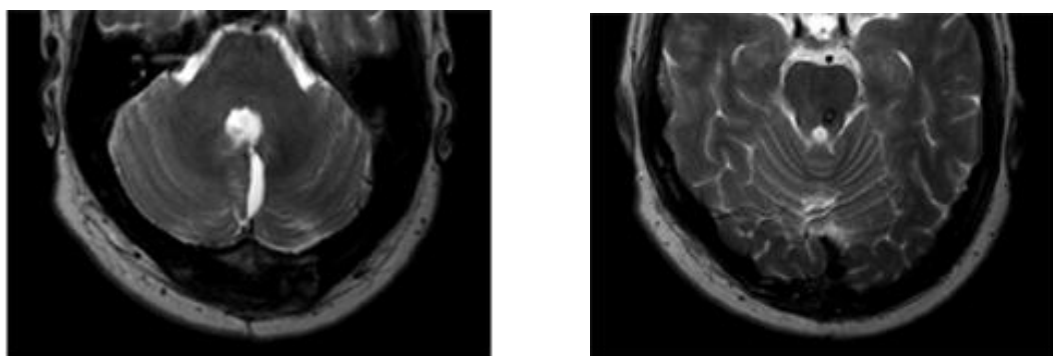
Postoperative axial MRI
